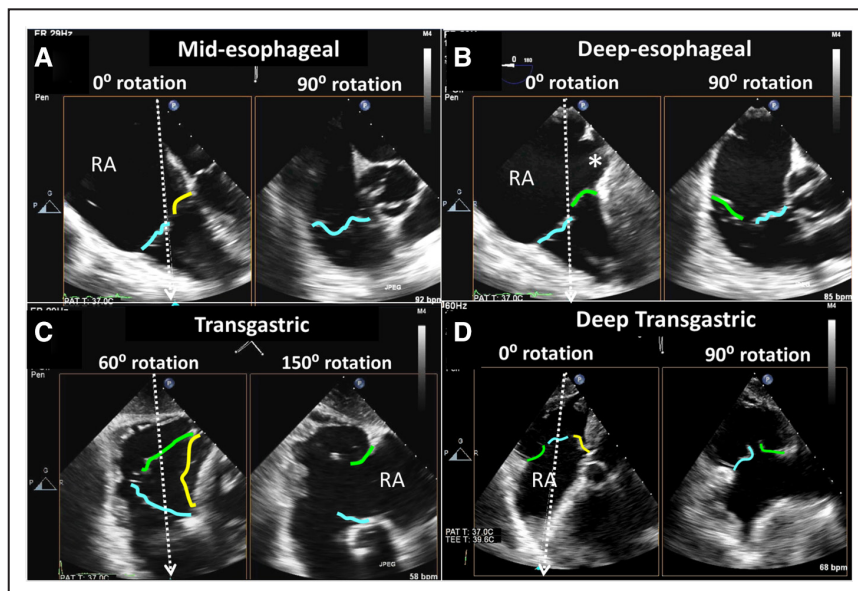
Multilevel imaging of the tricuspid valve (TV). A, An example of simultaneous multiplane imaging at the midesophageal depth. The 4-chamber view permits visualization of the septal and typically the anterior leaflet; simultaneous biplane imaging may help clarify which leaflet is imaged because the anterior leaflet is typically seen adjacent to the aorta. Low esophageal views (B) at the level of the coronary sinus (*) typically image the posterior and anterior leaflets. Advancing the TEE probe into the stomach and rotating $\approx 20\text{--}60^\circ$ produces the transgastric basal short-axis view (C), which is the only 2-dimensional (2D) view that usually provides simultaneous visualization of all 3 TV leaflets. Using the simultaneous multiplane imaging mode, all the leaflet coaptation points can be imaged. Advancing the transesophageal echocardiography probe along with rightward anterior flexion and returning the multiplane angle to $0\text{--}20^\circ$ produces a deep transgastric view of the TV (D).
